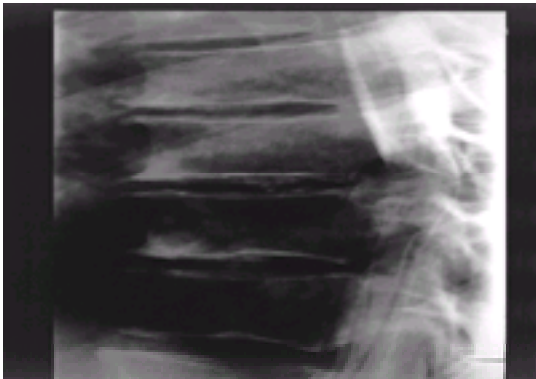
Myelogram showing posterior displacement of the cord by a calcified, central disc protrusion arising from the mushrooming out of the thoracic disc space. The postmyelogram CT scan of this same patient shows the abnormality more clearly and is the investigation of choice.
